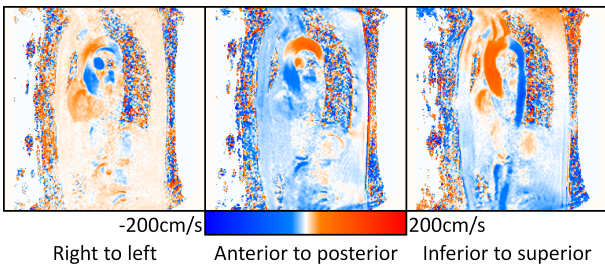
Three PC-MRI slices at peak systole showing the three measured velocity components. Blue and red respectively represent negative and positive values, while black indicates values near zero.
